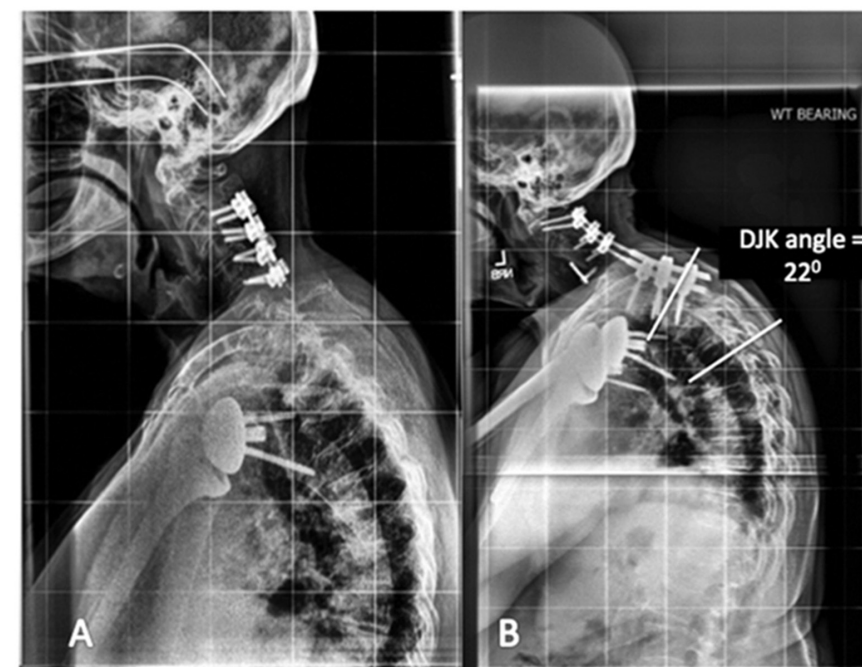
A. Preoperative lateral radiographs of a 75y female with a history of laminectomy and fusion with iatrogenic kyphosis and cervical sagittal deformity. B. Following C2-T2 anterior/posterior fusion, distal junctional kyphosis occurred with further loss of sagittal alignment.
